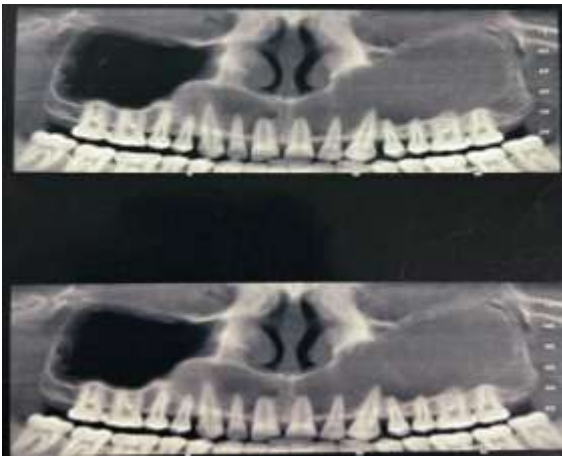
CBCT showing complete opacification of maxillary sinus
